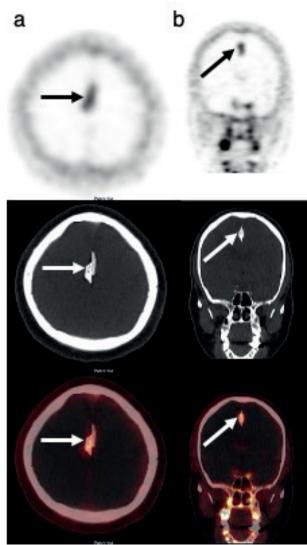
Axial (a) and coronal (b) images of an ¹⁸F-NaF PET/CT scan of a 61-year-old male with known prostate cancer. The ossification of the falx cerebri is evident on axial and coronal images. Note that falx cerebri ossification can vary in shape and location.
